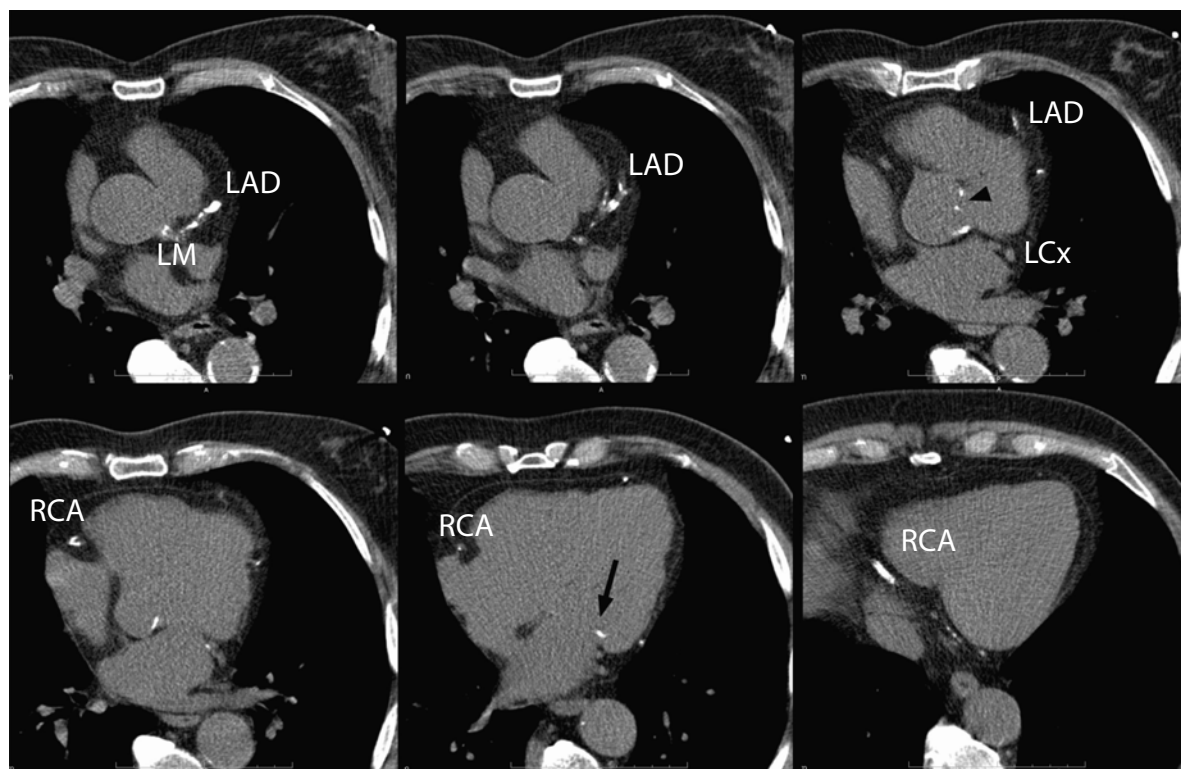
4-slice CT showing massive calcifications of all major coronary arteries in an asymptomatic person with increased cardiovascular disease risk. Note the aortic valve (*top, arrowhead*) and mitral valve (*bottom, arrow*) calcification. LM Left main coronary artery
